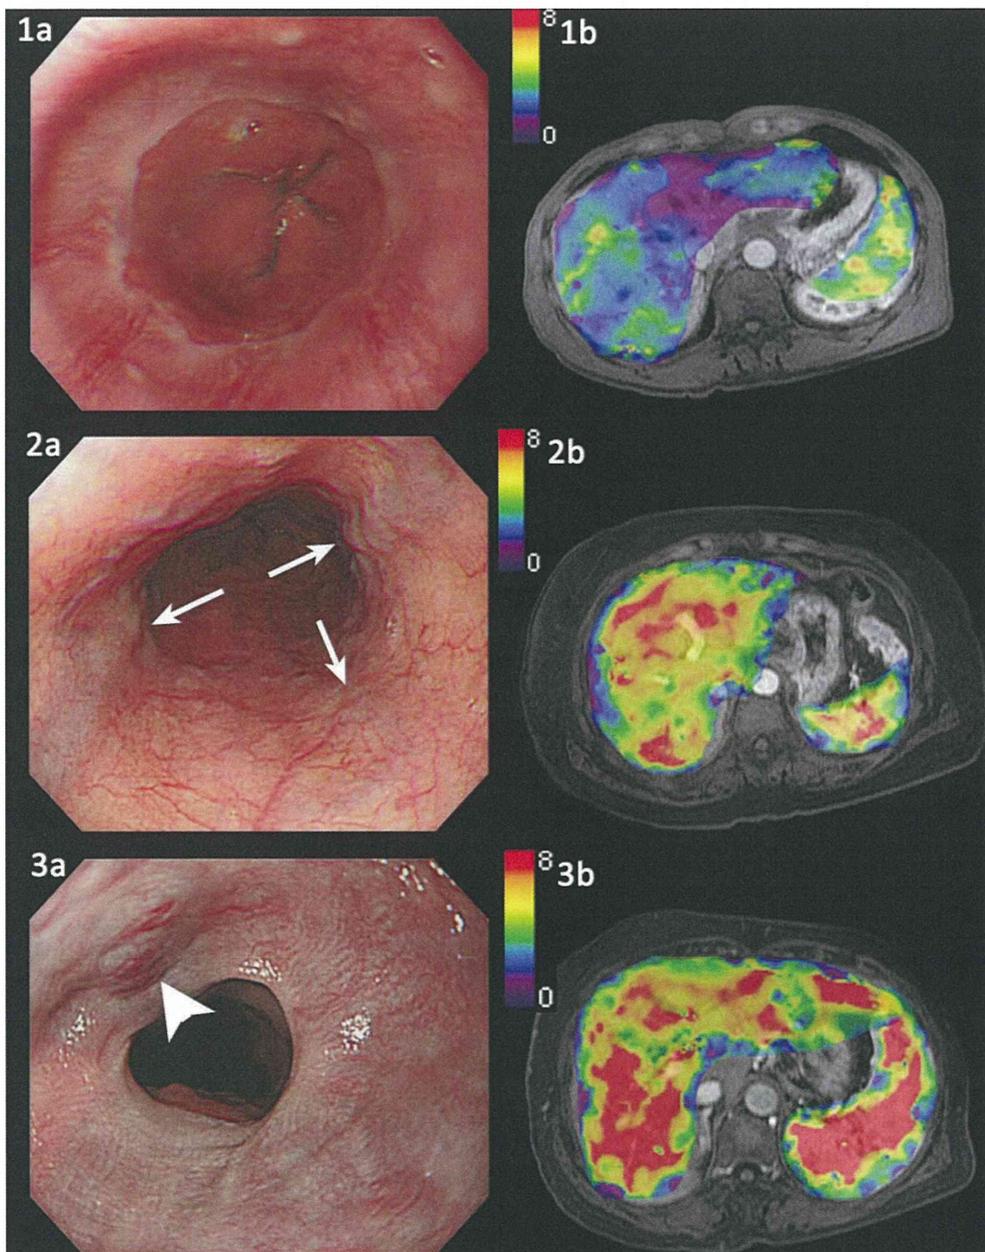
Case 1: A 53-year-old man with CLD without any GEVs (1a); liver and spleen elastograms superimposed on a contrast-enhanced MR image (1b) show low values for both liver (2.7 kPa) and spleen stiffness (4.7 kPa). Case 2: A 73-year-old woman with CLD with mild GEVs (2a, arrows); liver and spleen elastograms superimposed on a contrast-enhanced MR image (2b) show a high value for liver stiffness (6.4 kPa), but spleen stiffness remains low (6.6 kPa). Case 3: A 75-year-old woman with CLD with severe GEVs accompanied by the red-color sign (3a, arrowhead); liver and spleen elastograms superimposed on a contrast-enhanced MR image (3b) show high values for both liver (7.3 kPa) and spleen stiffness (12.0 kPa).
